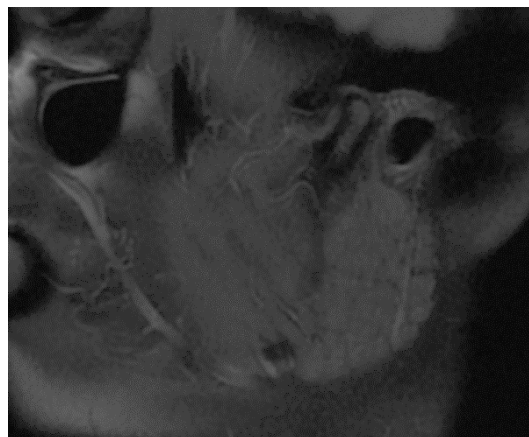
Condensed articular disc with anterior displacement relating to the mandibular condyle on PD MRI of the left temporomandibular joint in the sagittal plane with a closed mouth.
